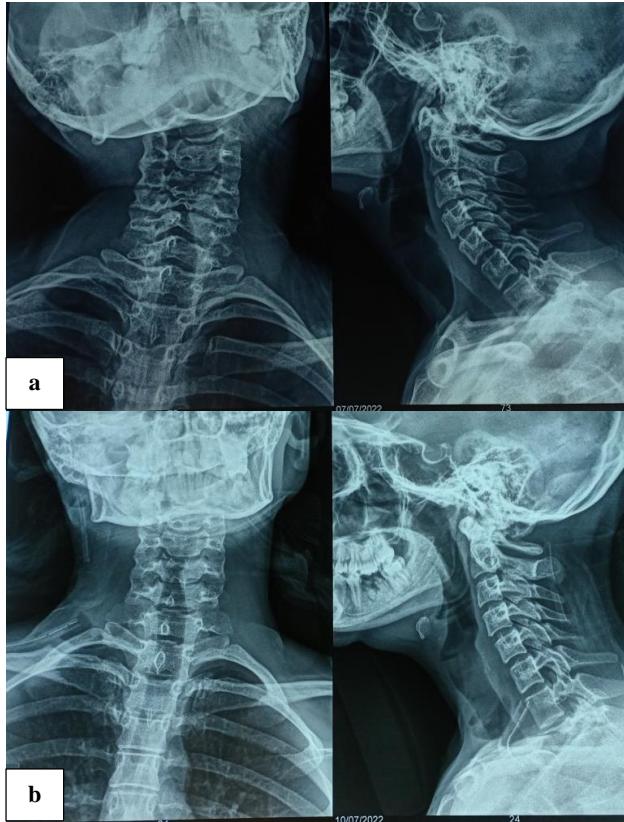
(a) Pre-op radiographs neck; (b) post-op radiographs neck.
